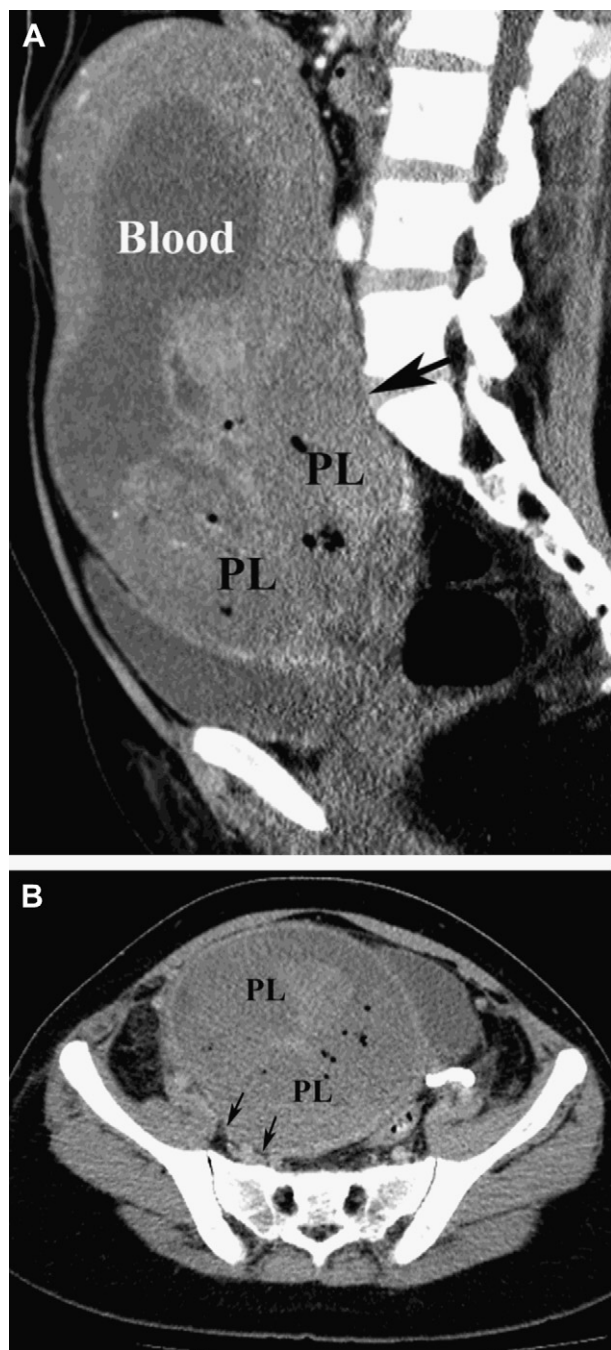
(A) Sagittal computed tomography showing a distended uterus filled with a large quantity of blood, a retained placenta (PL) trapped in the lower segment of the uterus, and an obscured interface between the placenta and the very thin posterior uterine wall (arrow). (B) Axial view showing an obscured interface (arrows) between the placenta and the very thin posterior uterine wall, corresponding to placenta accreta. Most of the placenta was removed by the use of ring forceps.
